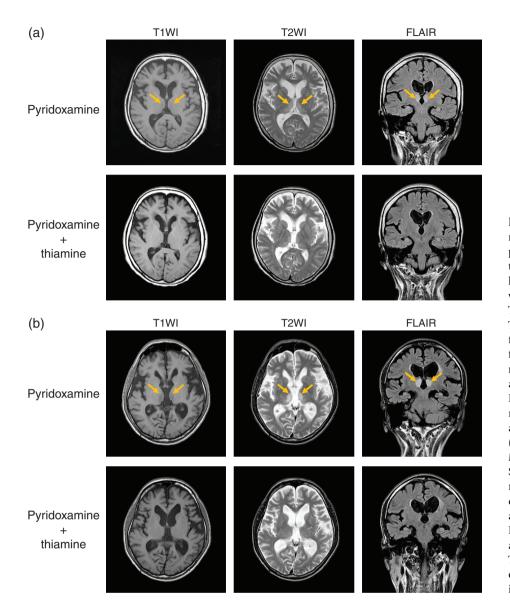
(a) Head magnetic resonance imaging (MRI) of patient C. Top: Bilateral medial thalamus lesions are shown in horizontal sections of T2weighted image (T2WI) and T1-weighted image (T1WI). The lesions were also confirmed in a coronal section of fluid-attenuated inversion recovery (FLAIR) image. Yellow arrows indicate the lesions. Bottom: After thiamine treatment, the abnormal intensities almost completely disappeared. (b) Head MRI of patient F. Top: MRI image scanned at onset. Similar to patient C, bilateral medial thalamic lesions were observed in case F. Yellow arrows indicate the lesions. Bottom: MRI image scanned after thiamine treatment. Thiamine administration markedly improved the abnormal intensities.
